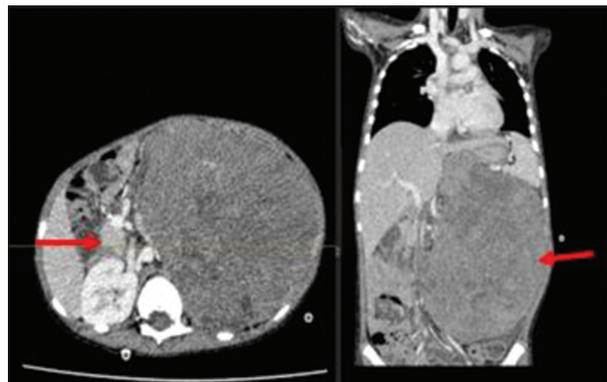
Contrast-enhanced computed tomography scan abdomen showed a 12 × 13.5 × 18 cm left renal mass, partially encasing the aorta and pushing abdominal vasculature and bowel loops medially, adherent to the tail of pancreas and splenic vasculature
